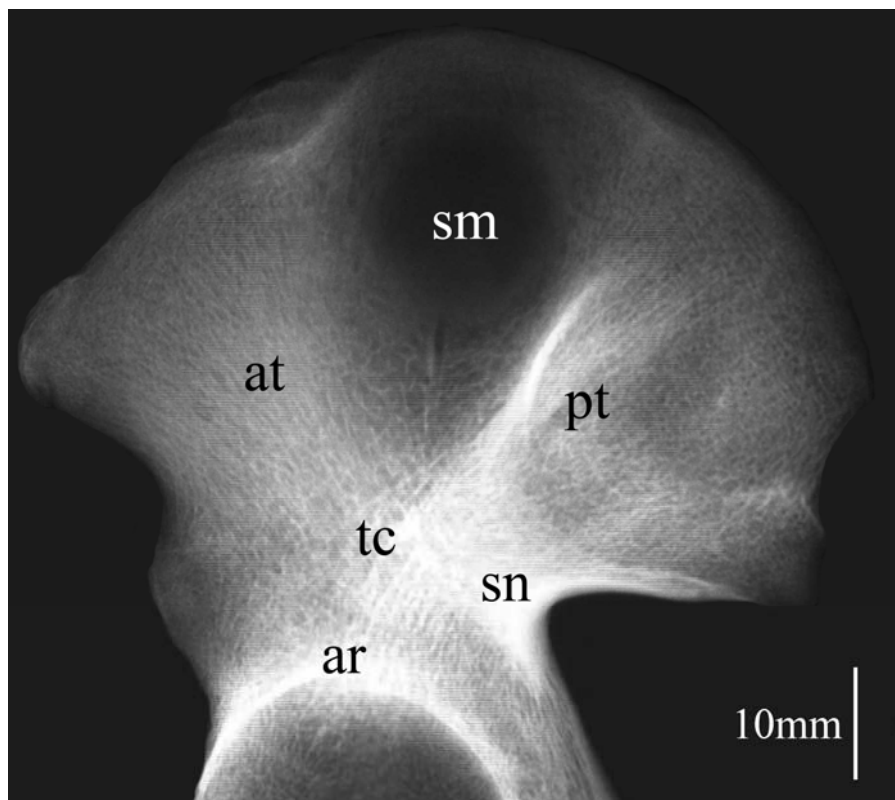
Conventional radiograph of an adult ilium. Principal features are labelled; posterior trajectory (pt), anterior trajectory (at), superior medial region (sm), trabecular chiasma region (tc), greater sciatic notch region (sn) and acetabular roof (ar).
